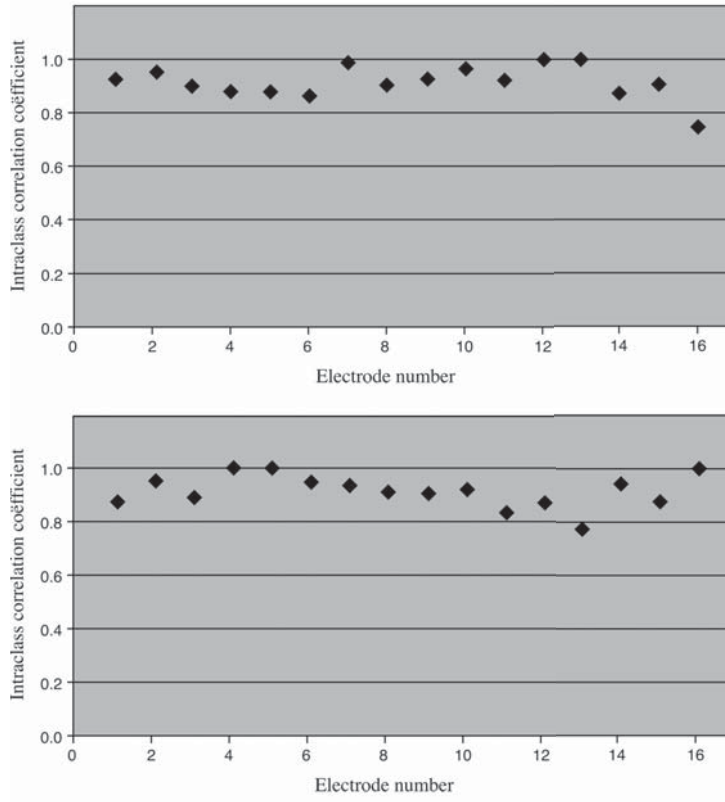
Reproducibility of the CT-based 3D-coordinate system: the ICC for ϕ (a) and ρ (b) of 16 electrode contacts localized by 4 observers.
